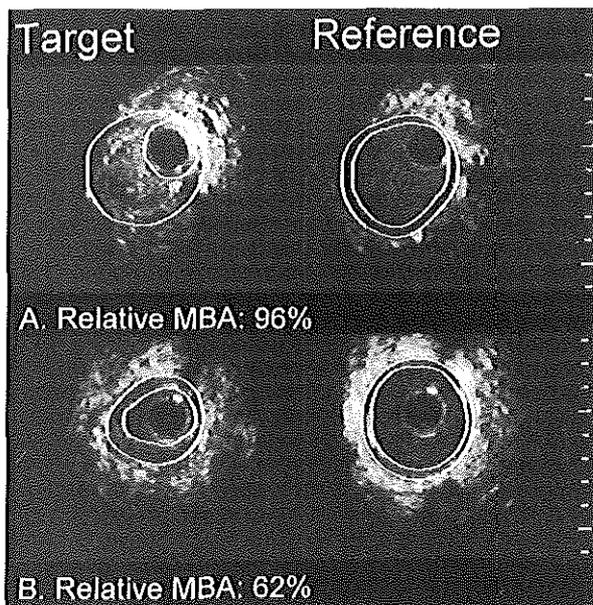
Intravascular ultrasound cross-sections obtained from renal arteries before intervention showing the adaptive remodeling (A) and the coarctation type of renal artery stenosis (B).
